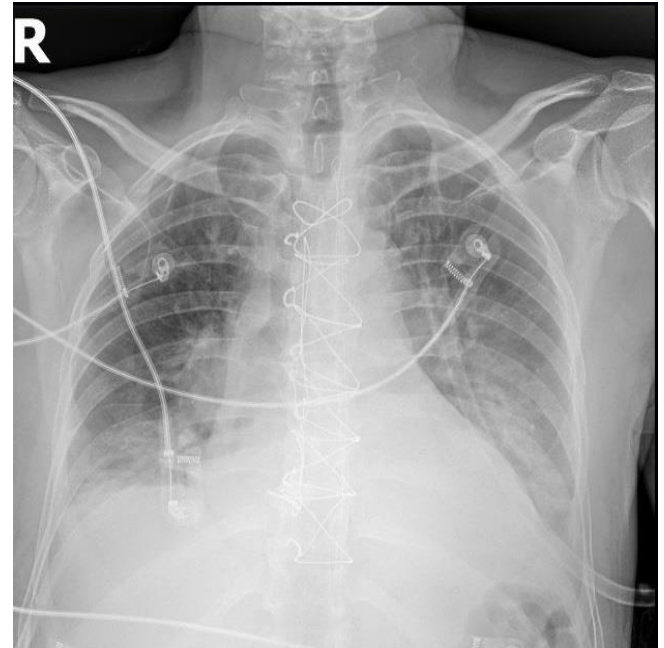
Chest radiography on the 3rd postoperative day demonstrating bilateral lung opacities
